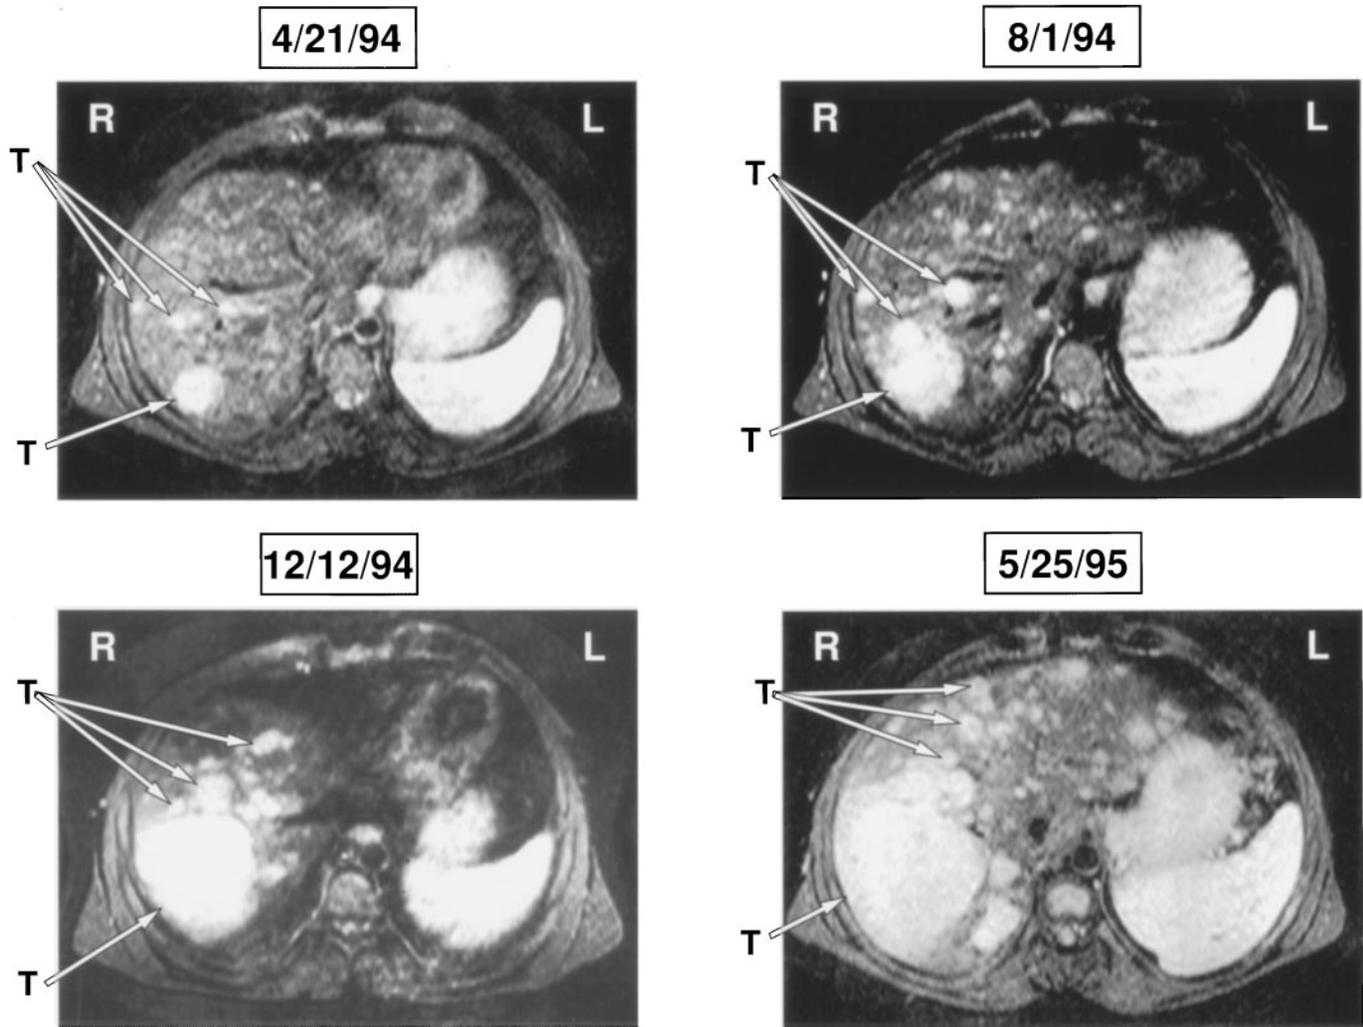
A patient with ZES and MEN1 with aggressive disease with rapidly growing hepatic metastases. Four consecutive short inversion-time inversion-recovery MRI show progressively enlarging right hepatic lobe metastases. This patient (NIH 181149) developed liver metastases shortly after presenting with a pancreatic tail tumor precluding surgical exploration. Metastatic gastrinoma was confirmed by percutaneous CT-guided liver biopsy. He failed treatment with various chemotherapy regimens as well as interferon- α . The patient died shortly after developing metastases in the bone. He also had pituitary and parathyroid disease.
